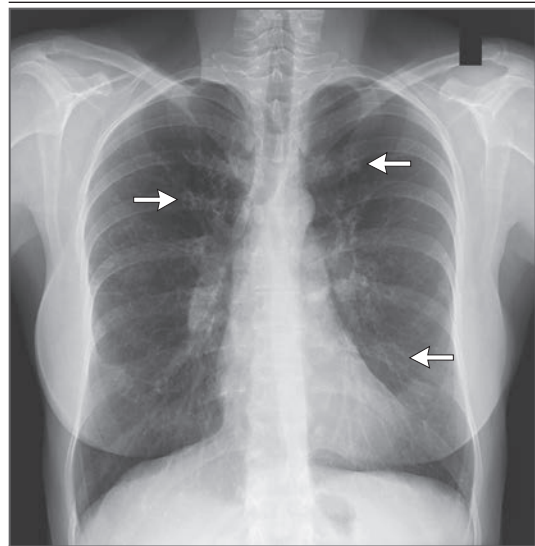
Radiograph of the Chest.
